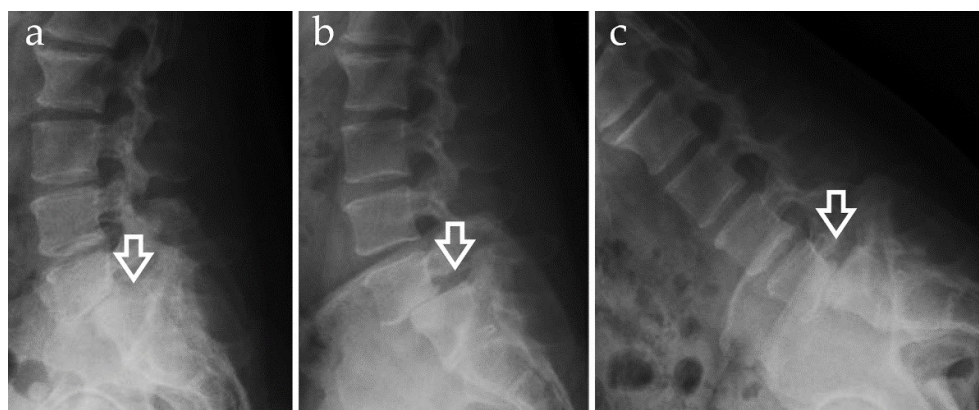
The radiographic diagnosis of spondylolisthesis starts with standing radiographs centered on the affected level (a). In order to assess the mobility of the level and the instability of the spine segment, flexion (b) and extension lateral (c) views are obtained.
